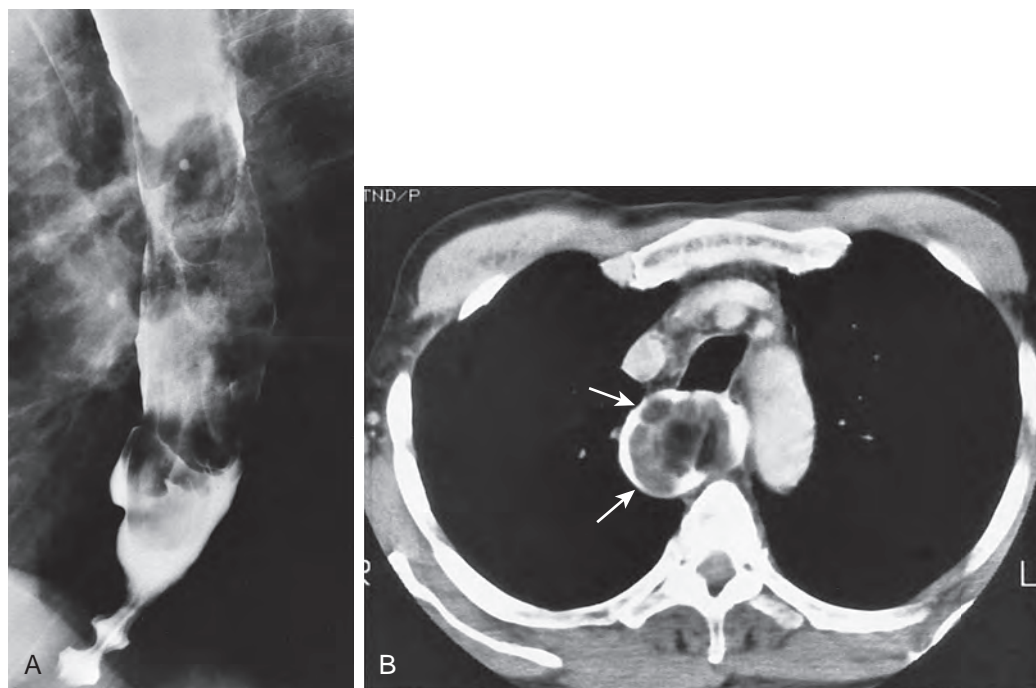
Fibrovascular polyp. A. Barium study shows an expansile mass extending into the distal thoracic esophagus. In contrast to the polyp in Figure 22-13A, this lesion has a lobulated contour, so it could be mistaken for a malignant esophageal tumor. B. Axial CT scan also shows an expansile mass (arrows) in the esophagus with intraluminal contrast material surrounding the lesion. In this case, note the heterogeneous appearance of the polyp with areas of fat juxtaposed with areas of soft tissue density. (From Levine MS, Buck JL, Pantongrag-Brown L, et al: Fibrovascular polyps of the esophagus: Clinical, radiographic, and pathologic findings in 16 patients. *AJR* 166:781–787, 1996.)
